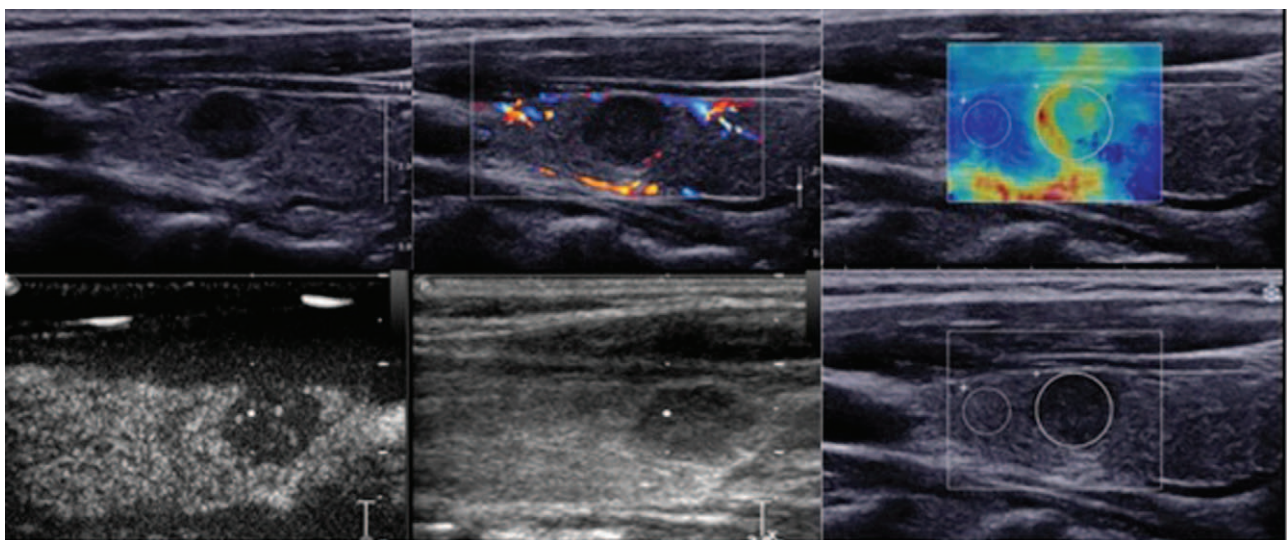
Multimode ultrasonic features of the nodule in the right lobe in a 42-year-old woman with adenoid cystic carcinoma of the submaxillary gland metastasized to the thyroid.
